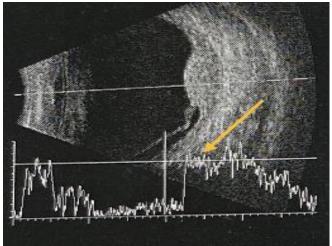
A-mode ocular ultrasound shows low signal attenuation suggesting ocular metastasis (AVISO echography, Ophtalmology Department, Hassan II University Hospital of Fez)
